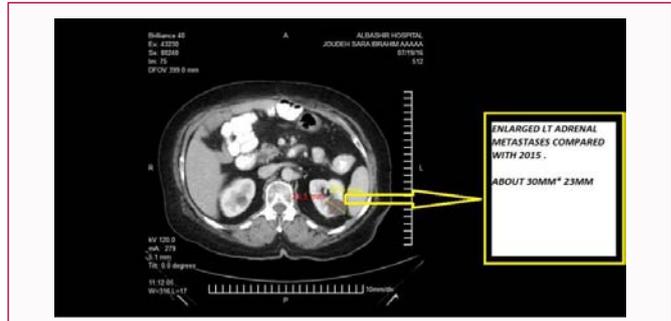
CAP-CT scan was revealed left soft tissue density adrenal mass (3.0*2.3) on July/2016.
